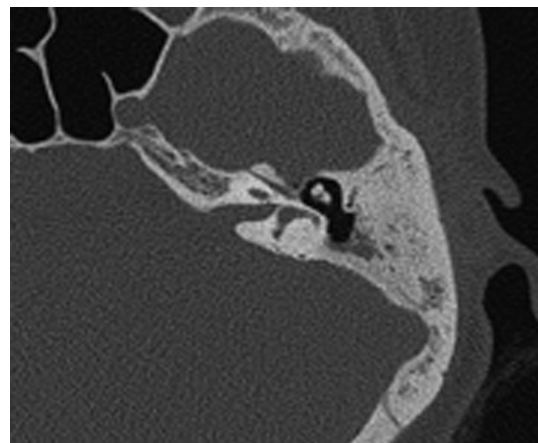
Temporal Bone Computed Tomography (TBCT) axial view.
